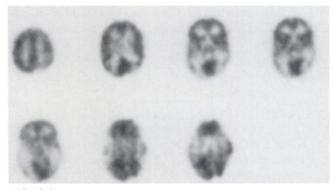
FDG study with the ECAT tomograph. This interictal study of a partial epilepsy patient is displayed with the subject's right hemisphere on the right side of each image. Both investigators reported left lateral temporal hypometabolism (seen on the three most inferior image planes). One investigator reported left mesial temporal hypometabolism, but the other did not. Other areas of possible hypometabolism (e.g., the right parietal area on the image plane to the right of the upper row) were not considered clearly abnormal.
